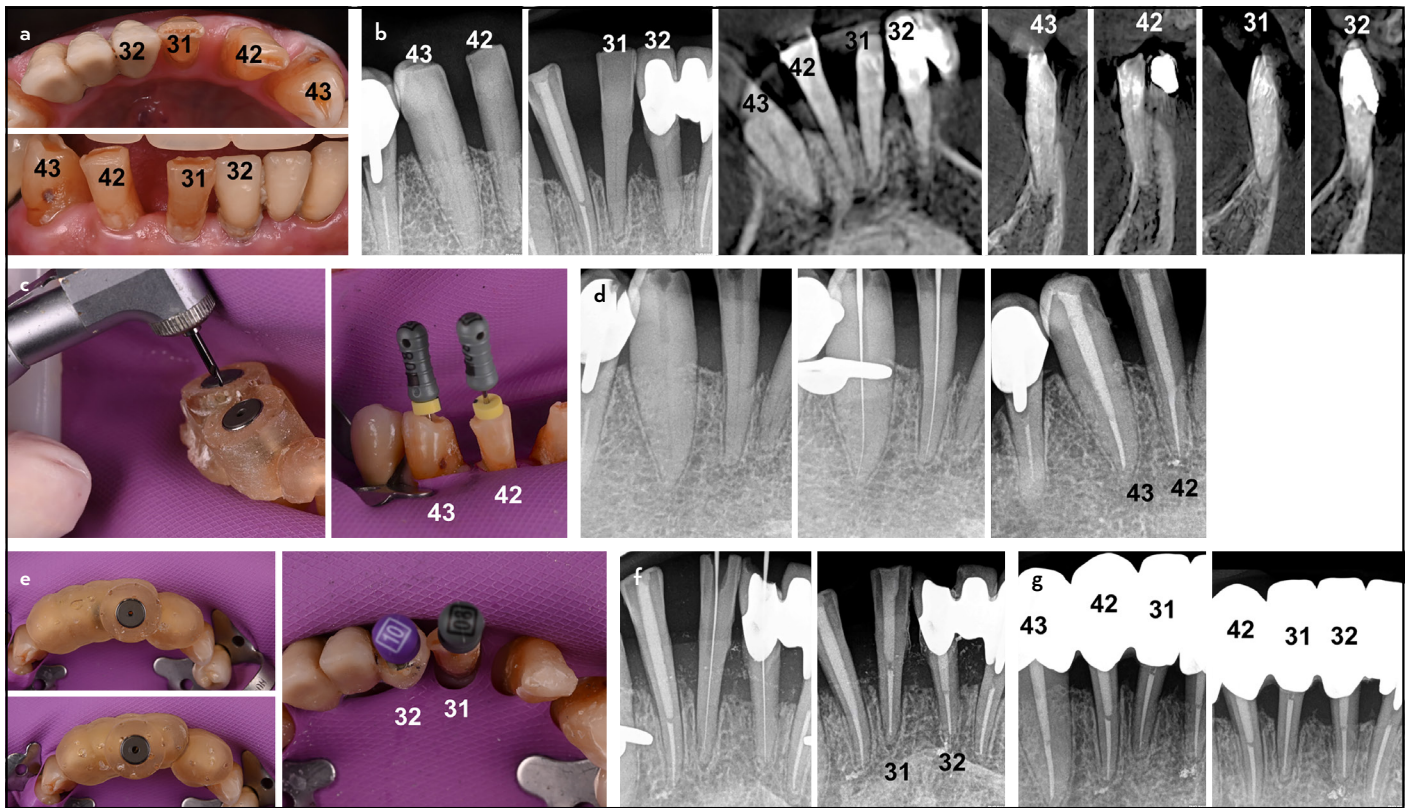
Cases 2, 3, 4 and 5. (a) Clinical photographs of target teeth (31, 32, 42, and 43). (b) Preoperative radiographs and CBCT scans. (c) Guided access using a single template with two sleeves for teeth 42 and 43, respectively. (d) Radiograph monitoring the trajectory of the bur, working length, and post-operative radiographs of teeth 42 and 43. (e) Separate templates for guided access of teeth 31 and 32, after opening the prosthetic crown with a transmetal bur. (f) Radiographic sequence of treatment for teeth 31 and 32, including immediate postoperative status. (g) One-year follow-up CBCT: Cone beam computed tomography
